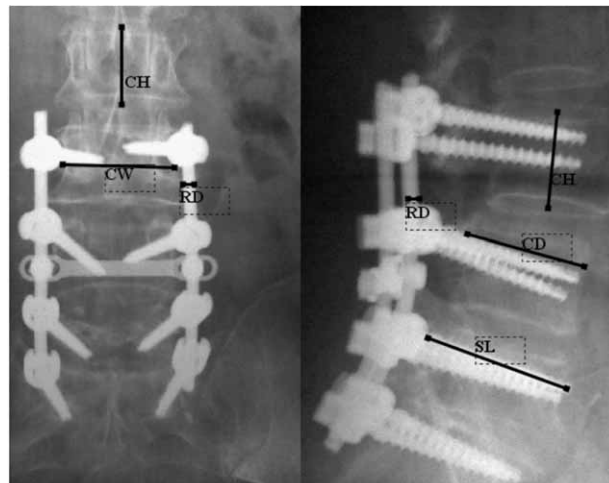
Vertebral body depth, width and height – CD, CW, CH, rod diameter – RD, and screw length SL on the X-ray scans after posterior fixation of lumbar spine.
